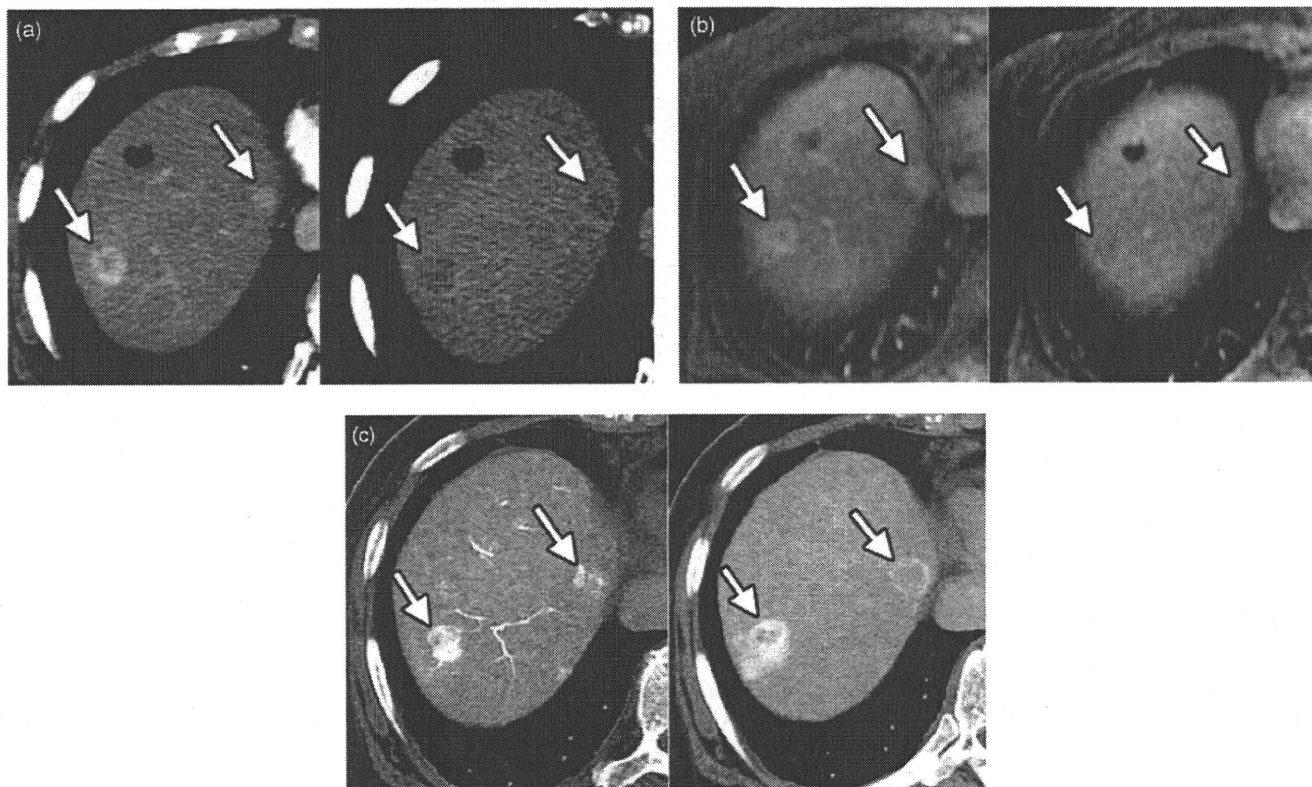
A 74-year-old female with C-virus related chronic hepatitis with two hypervascular hepatocellular carcinomas (HCC) in S8 (19 mm) and S4 (11 mm). (A) Arterial dominant phase (left) of dynamic CT shows two enhanced nodules (arrows). On equilibrium phase (right), both of them demonstrate hypodensity indicating wash out of contrast medium. (B) On dynamic MRI, they show definite enhancement on arterial dominant phase (left, arrows) and wash out on equilibrium phase (right, arrows). (C) Early-phase of CT during hepatic arteriography (CTHA) reveal them as definitely hyperdense nodules (left, arrows) and they demonstrate wash out of contrast medium with surrounding corona enhancement on late-phase (right, arrows).
